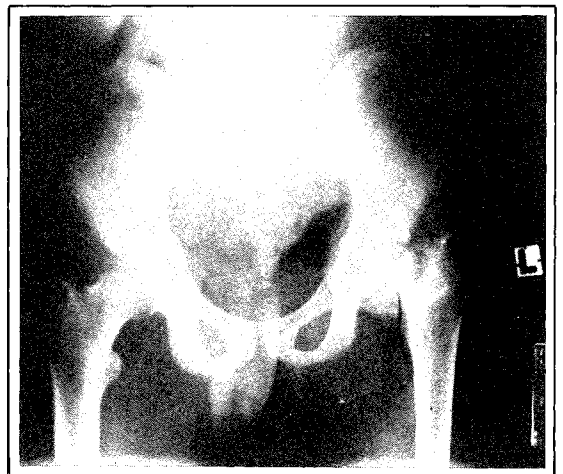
A pre-operative radiograph of Case 2 with coxa vara and a vertical pseudoarthrosis.
